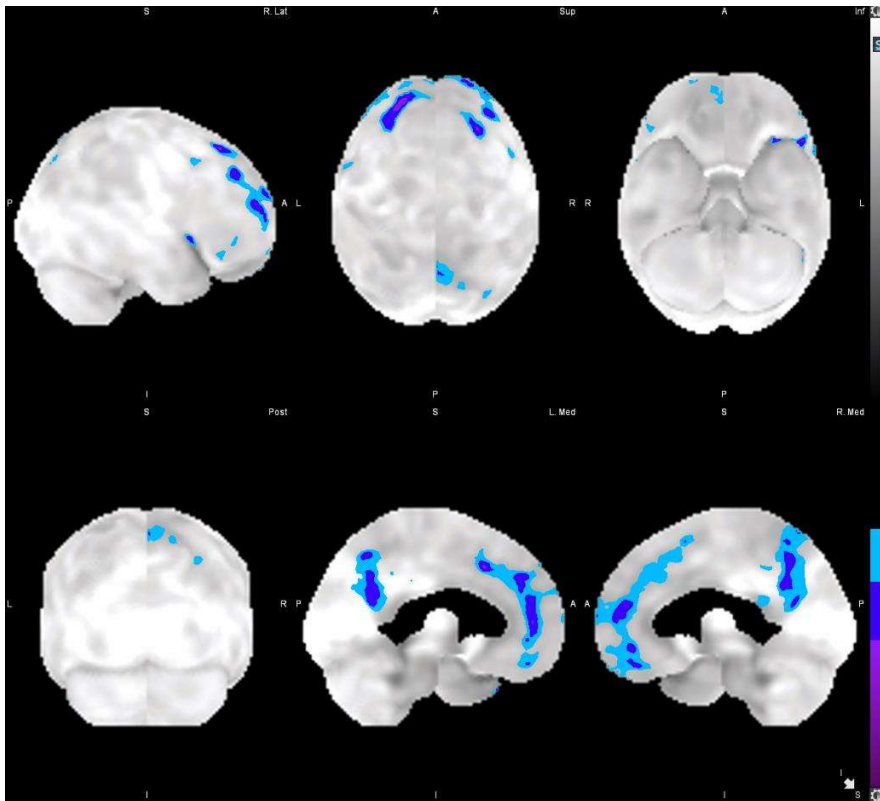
FDG-PET scan of the brain showing a mildy decreased metabolism in the frontal areas and precuneus.
